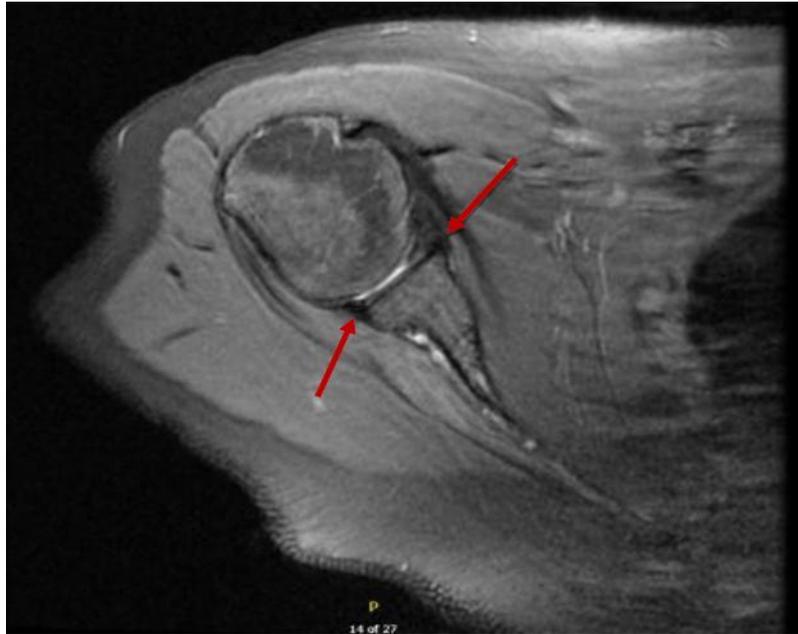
MRI of right shoulder showing a SLAP lesion with reverse Bankart lesion.
